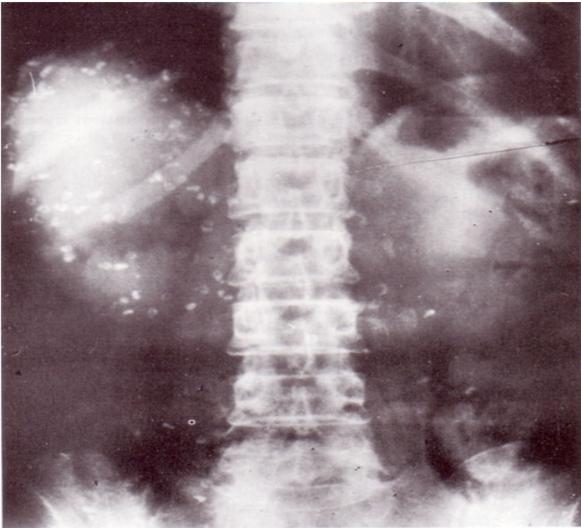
X-ray of the abdomen, without any preparation, showing multiple calcified nymphs of a pentastome.
